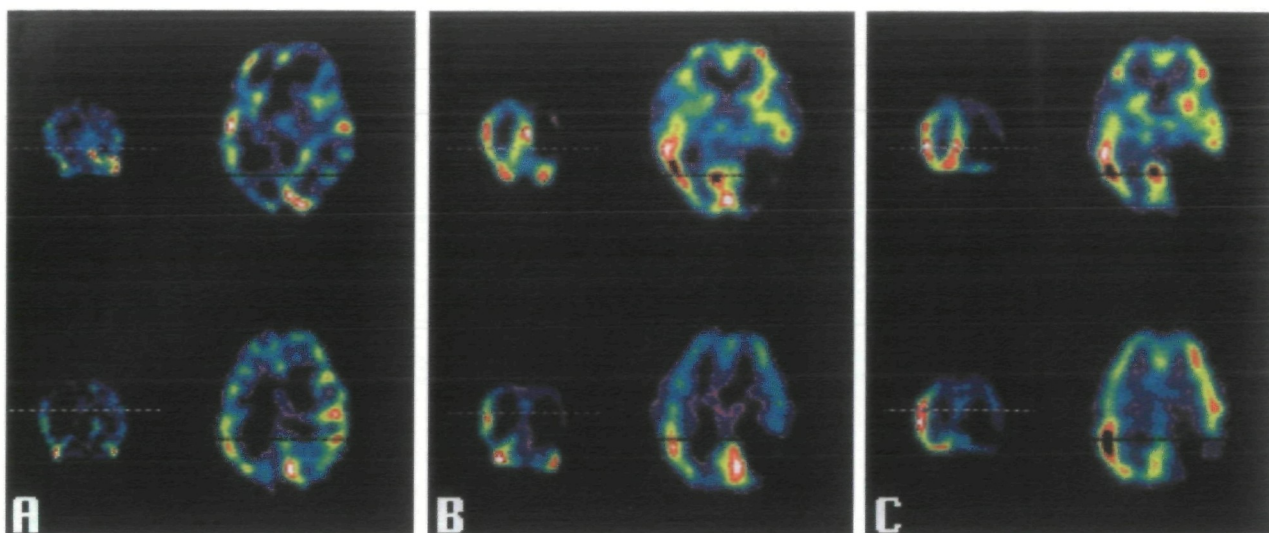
Single-photon emission computed tomography images at 15 days (A), 4 months (B), and 8 months (C) after infarction. At each date, axial and corresponding coronal images are shown at two levels. In all images, red represents highest tracer uptake; deep blue, lowest; and blue, green, and yellow, intermediate levels in ascending order. All images are normalized to their own maximum. On the initial study there is greater uptake in the left posterior hemisphere, corresponding to the infarct on computed tomography and magnetic resonance imaging. On later studies there is much lower tracer uptake in this region.
